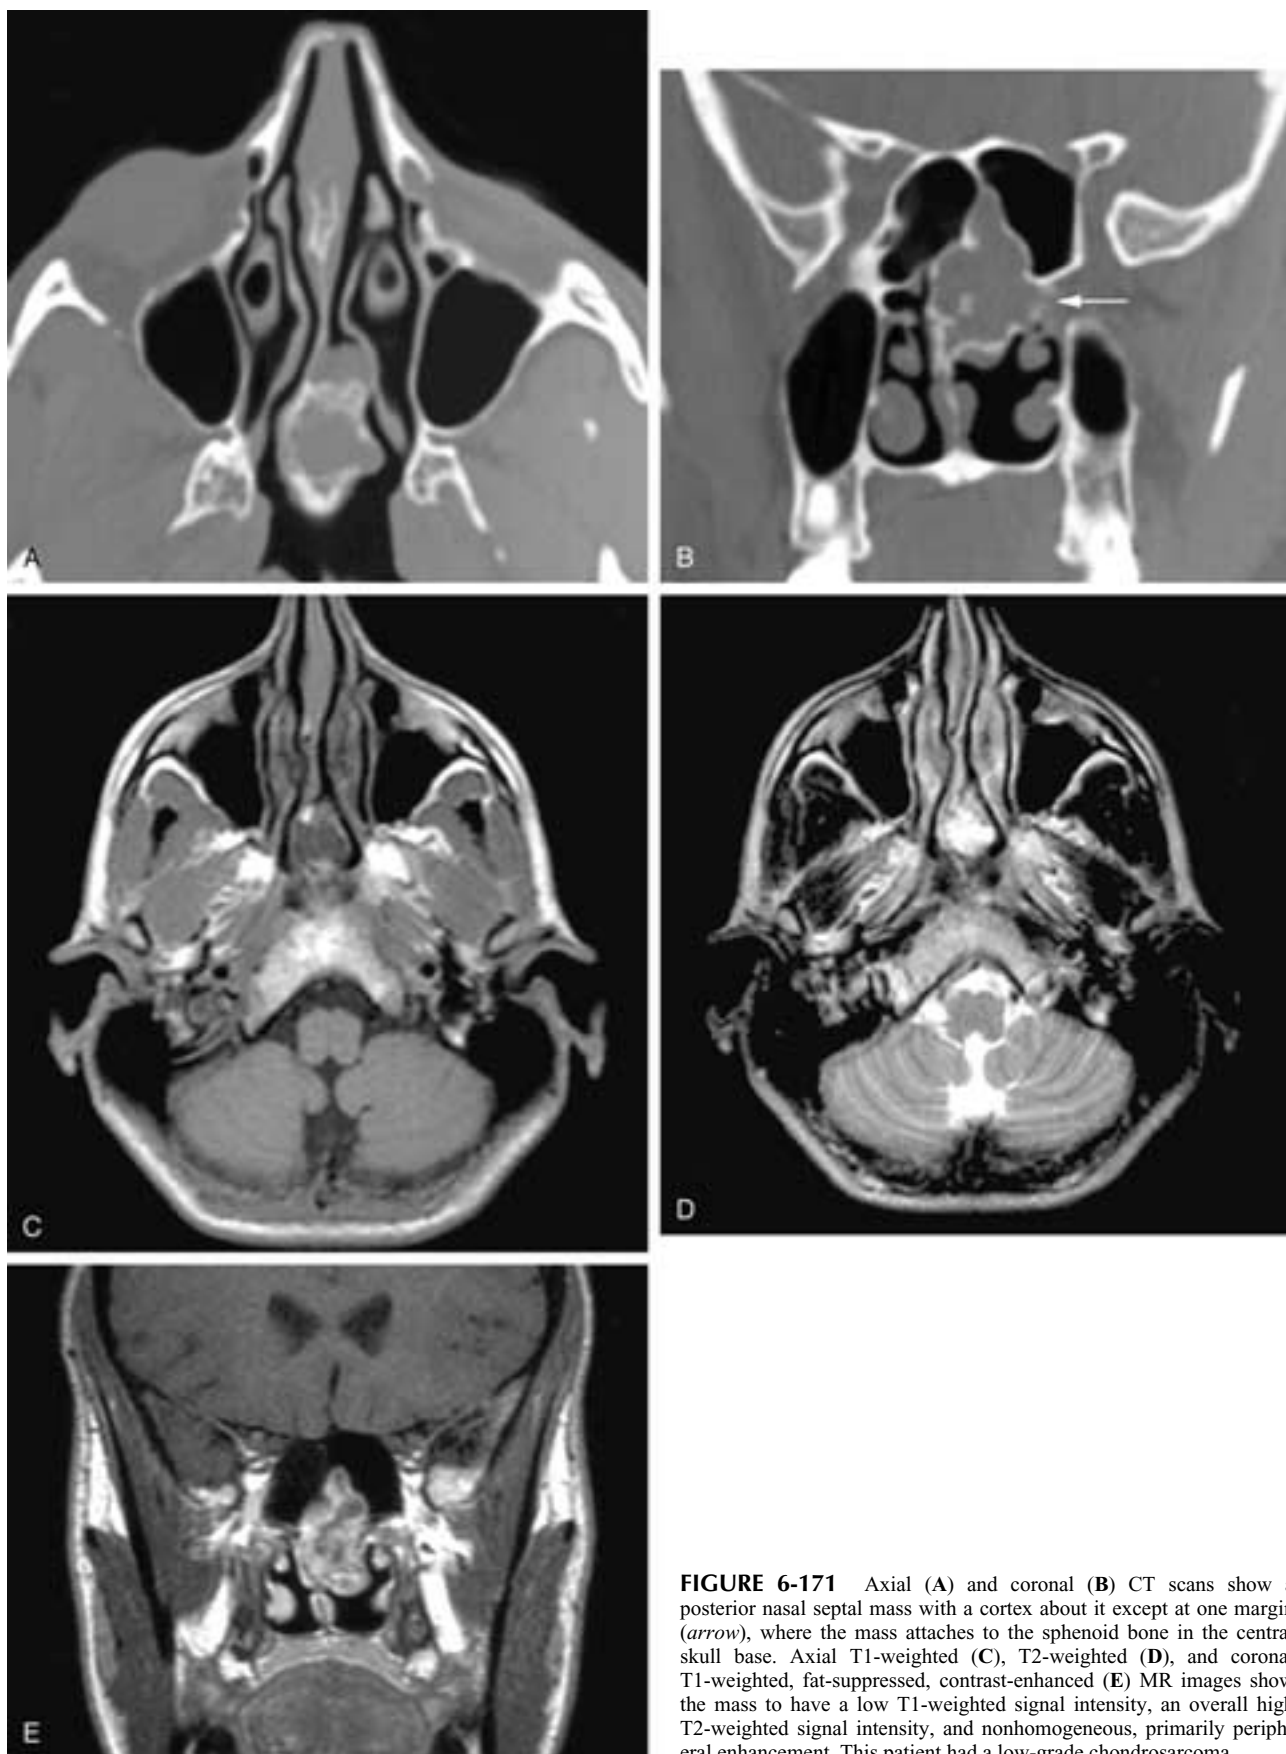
Axial (A) and coronal (B) CT scans show a posterior nasal septal mass with a cortex about it except at one margin (*arrow*), where the mass attaches to the sphenoid bone in the central skull base. Axial T1-weighted (C), T2-weighted (D), and coronal T1-weighted, fat-suppressed, contrast-enhanced (E) MR images show the mass to have a low T1-weighted signal intensity, an overall high T2-weighted signal intensity, and nonhomogeneous, primarily peripheral enhancement. This patient had a low-grade chondrosarcoma.
